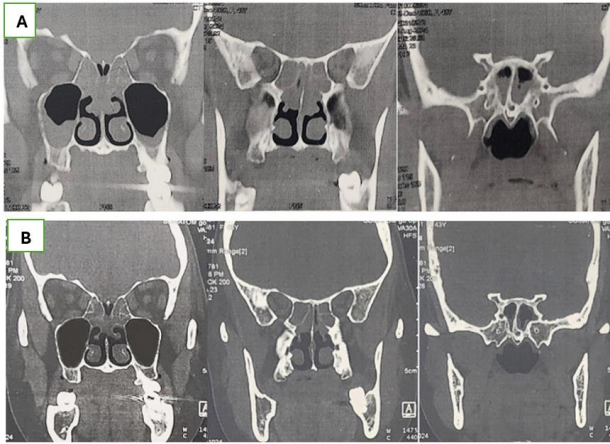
A: CT scan for a case with Lund Mackay score 16 before administration of dupilumab. B: CT scan for the same case with Lund Mackay score 10 after 6 months of administration of dupilumab
